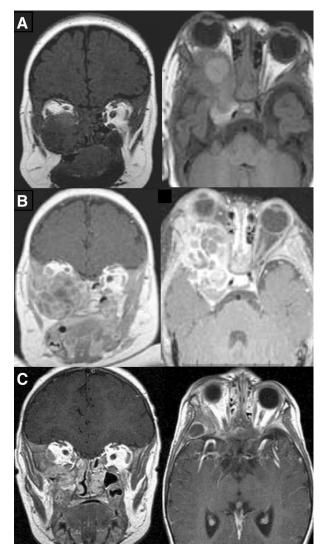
T1-weighted MRI, coronal and axial cuts at (A) age 2 months without gadolinium, (B) at 5 months with gadolinium, and (C) at 18 months with gadolinium, shows regression of a heterogeneously enhancing right orbital mass with involvement of the maxillary and ethmoid sinuses, pterygopalatine fossa, infratemporal fossa, middle cranial fossa, and right cavernous sinus.
